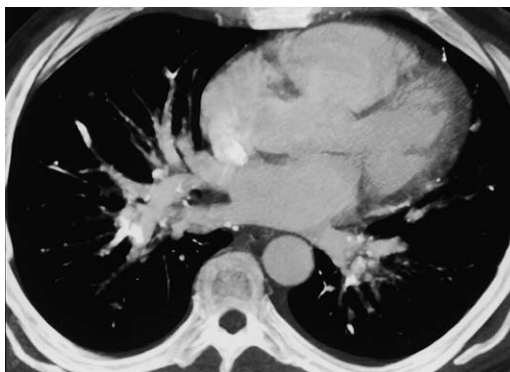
A 55-year-old man with cirrhosis status post–endoscopic injection sclerotherapy of a gastric varix using a mixture of acrylic glue (n-butyl-2-cyanoacrylate) and lipiodol (iodized oil). Maximum intensity projection images from a contrast-enhanced CT shows areas of increased attenuation in multiple segmental and subsegmental pulmonary arteries, consistent with embolization of the acrylic glue mixture. The iodized oil allows for radiographic visualization.
